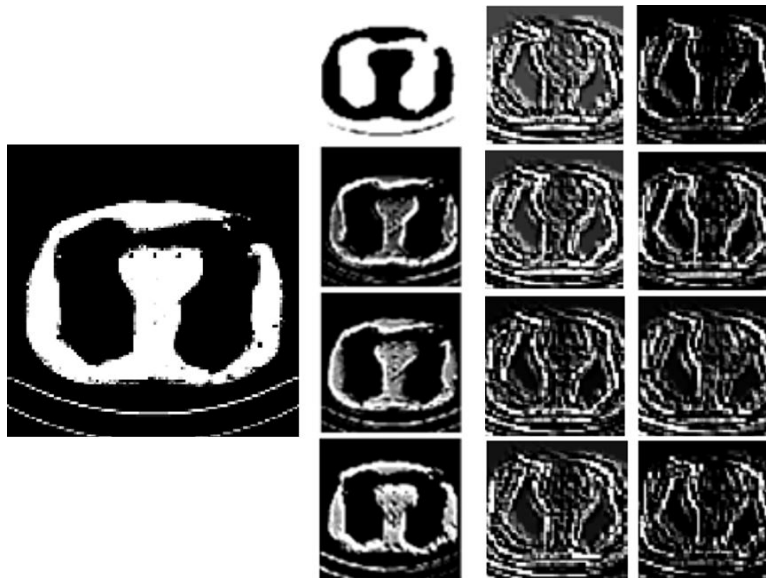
AFMs for the CT image data sets demonstrate the importance of edge information on this data set.
